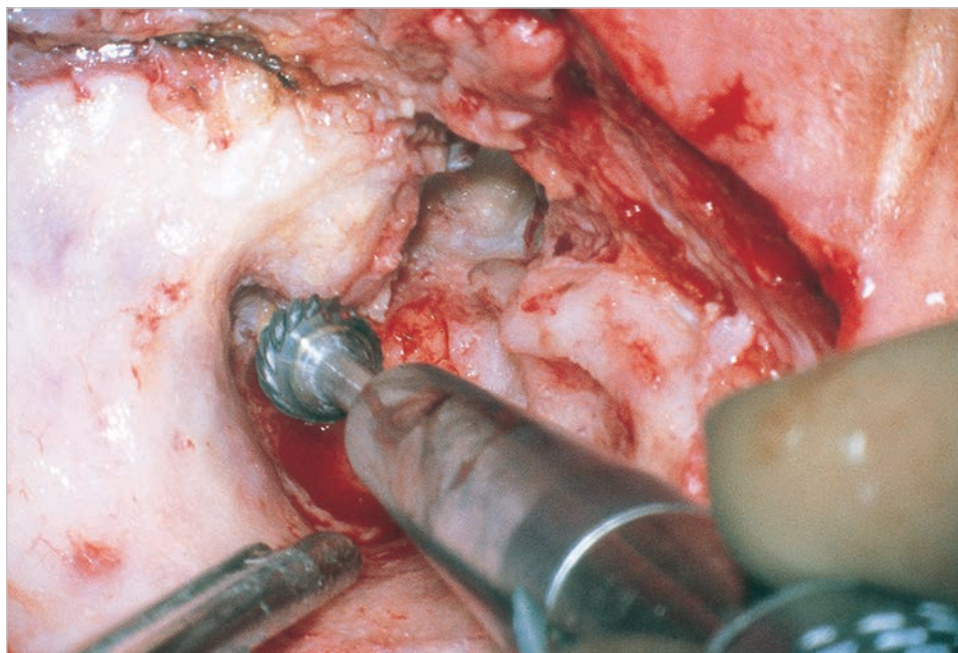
A massive bone shown on the coronal CT (► Fig. 7.447) is now removed with a large cutting burr.
